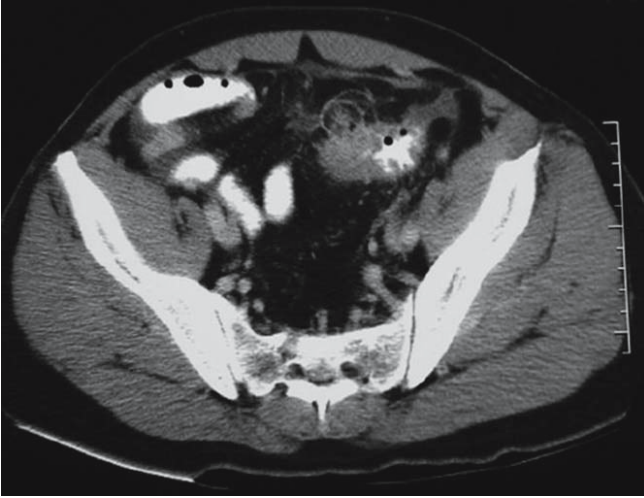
Contrast enhanced CT scan of the lower abdomen showing thickening of the sigmoid colon with diverticula and surrounding inflammation (acute diverticulitis)
